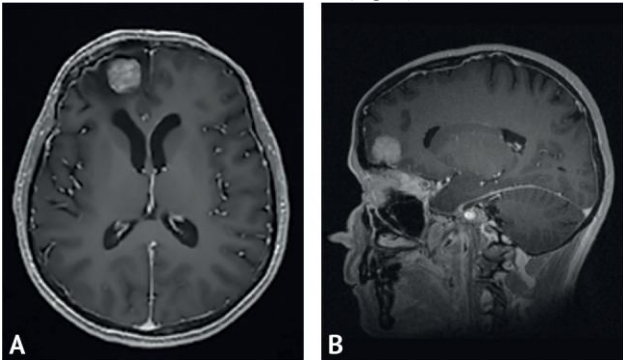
Results of preoperative magnetic resonance imaging with intravenous contrast enhancement in T1 FSPGR mode in axial (A) and sagittal (B) projections. In the basal parts of the right frontal region, an extracerebral formation of a rounded shape, with a clear even contour, actively and uniformly accumulating contrast agent is determined
